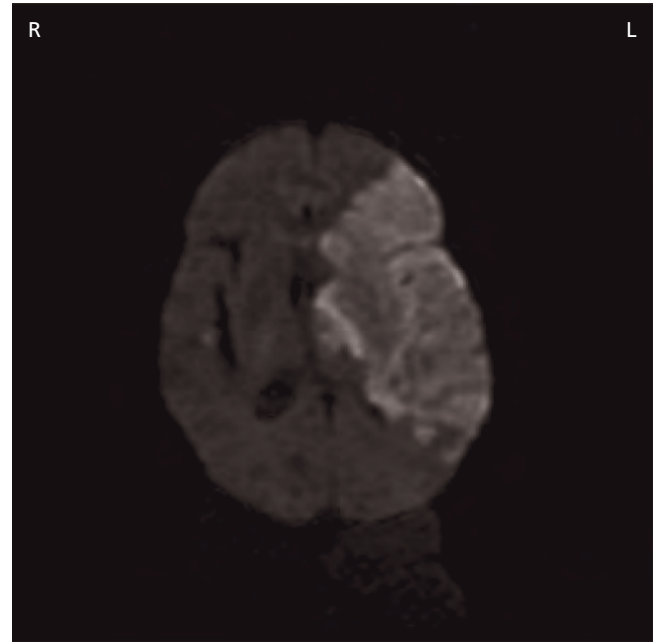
Complete MCA territory infarction (diffusion weighted MRI).
